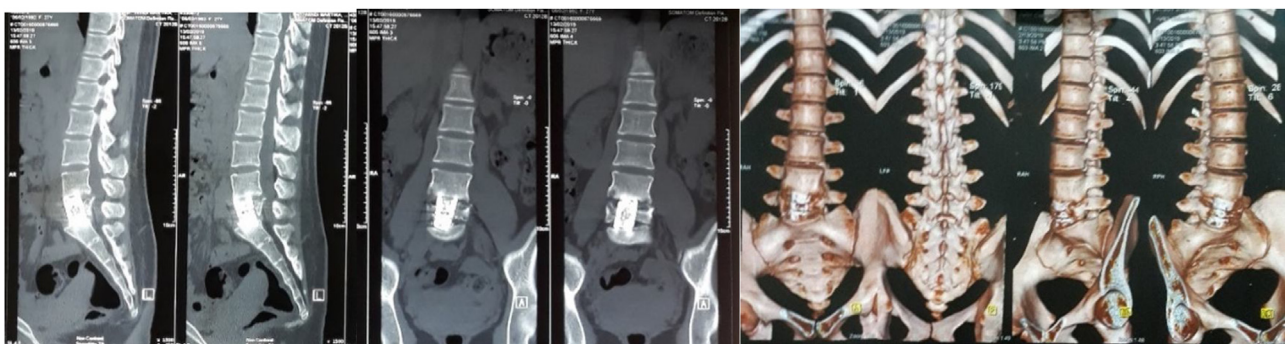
Three Months Postoperative CT-Scan. Expendable mesh was visible through 2D/3D CT-scan examination. Shown good ossification and fusion around L4-S1 and expendable mesh cage corpus replaced showed internal ossification.
